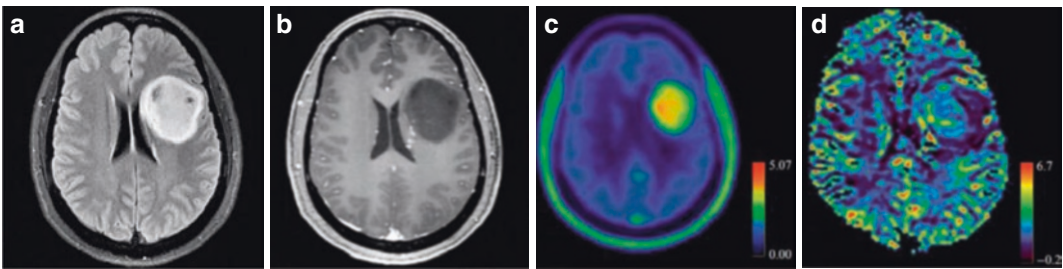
IDH-mutant astrocytoma without 1p/19q co-deletion. A 31-year-old female patient, whose integrated PE/MRI shows a round mass in the left frontoparietal lobe. Transverse FLAIR shows heterogeneous hyperintense signals without significant perilesional edema (a); contrast-enhanced scan shows no significant contrast enhancement (b); transverse ^{18}F -FET PET shows significantly enhanced uptake within the lesion, with TBR_{mean}
